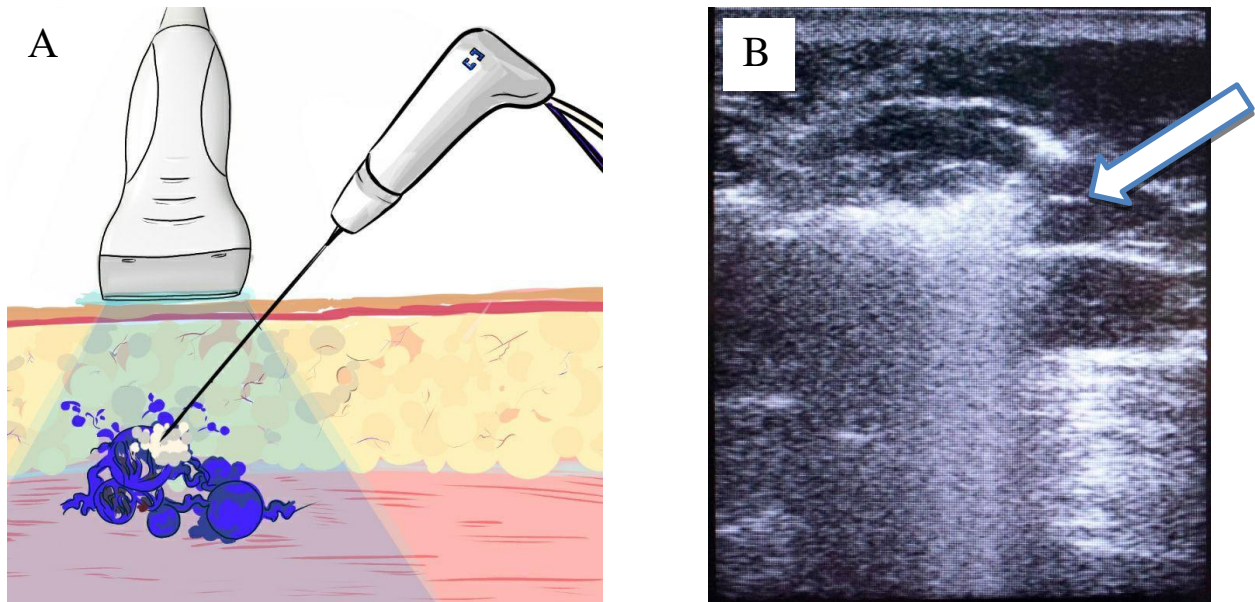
Surgical intervention with ultrasound (US) control (A) and the results of US examination in B-mode (B). Echo-positive signals in the radiofrequency ablation zone (arrow)
